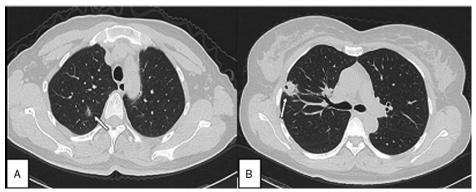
A: Chest CT showing a solitary nodular ground-glass opacity (SNGGO) in the right S⁶ (green arrow, patient 7). B: Chest CT showing a tumour with lobulation sign, burr sign, pleural sag and vascular convergence in the right S³ (green arrow, patient 5).
